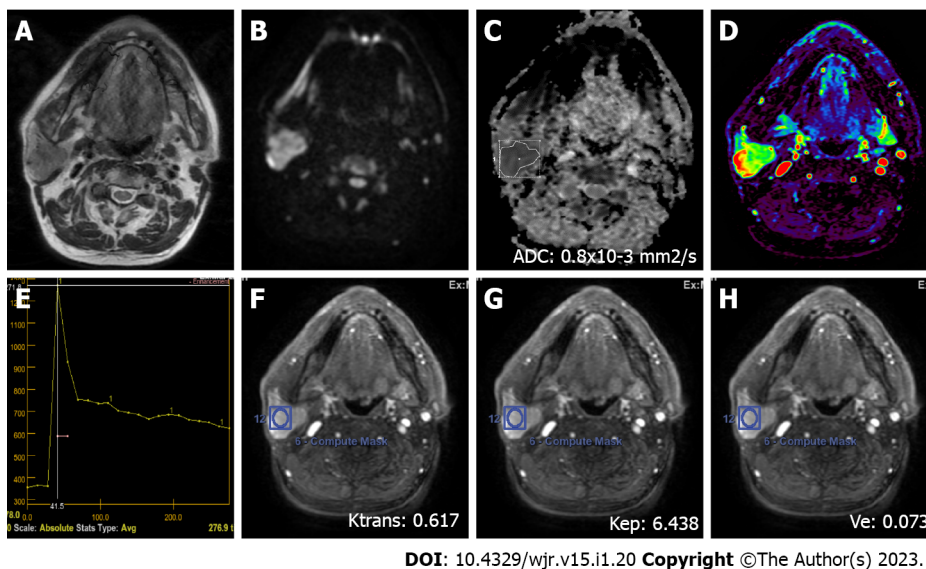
A 72-year-old male patient with a Warthin's tumor in the right parotid gland. A: On axial plane T2-weighted image, a mildly hypointense (compared to the gland), smooth-contoured mass localized in the center of the parotid gland is observed; B: On the diffusion-weighted image, the mass appears to be hyperintense; C: ADC value was $0.8 \times 10^{-3} \text{ mm}^2/\text{s}$ on the apparent diffusion coefficient map; D: The mass is hyperperfused on color-coded perfusion image; E: Type B time intensity curve shows a washout ratio of 75%; F, G, and H: K_{trans} , K_{ep} , and V_e values on quantitative perfusion images were 0.617 min^{-1} , 6.438 min^{-1} , and 0.073 , respectively. ADC: Apparent diffusion coefficient.
